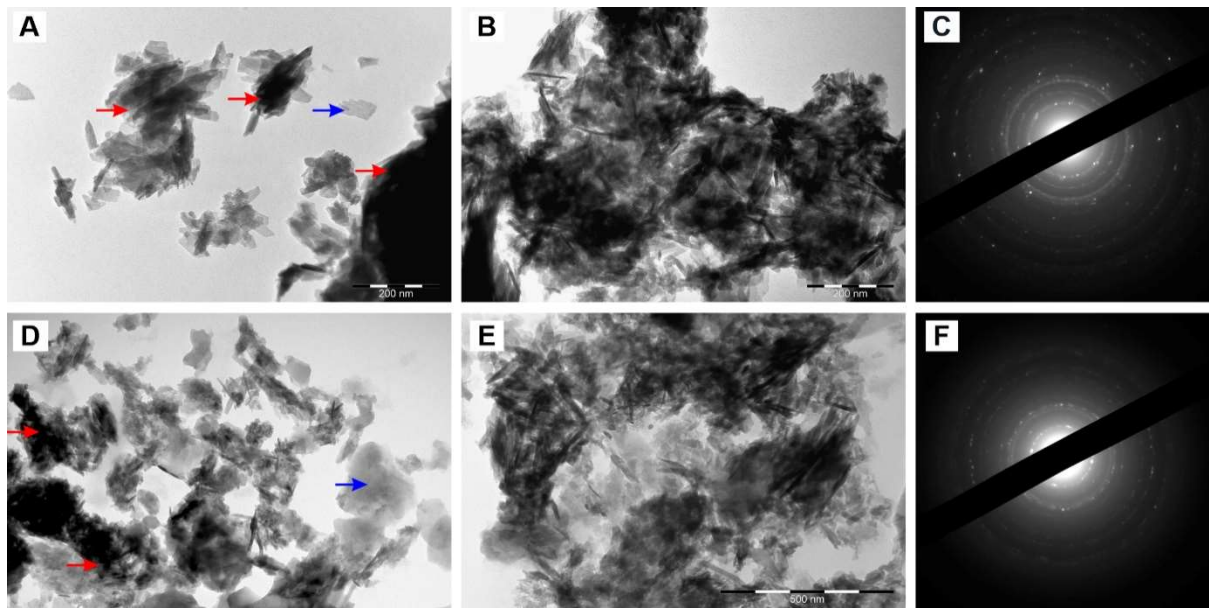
A,D Samples deposited directly on the grid; B,E Ultrasonicated and centrifuged samples; C,F SAED patterns associated with the samples (from Paica et al., 2023 © Elsevier Inc.).
